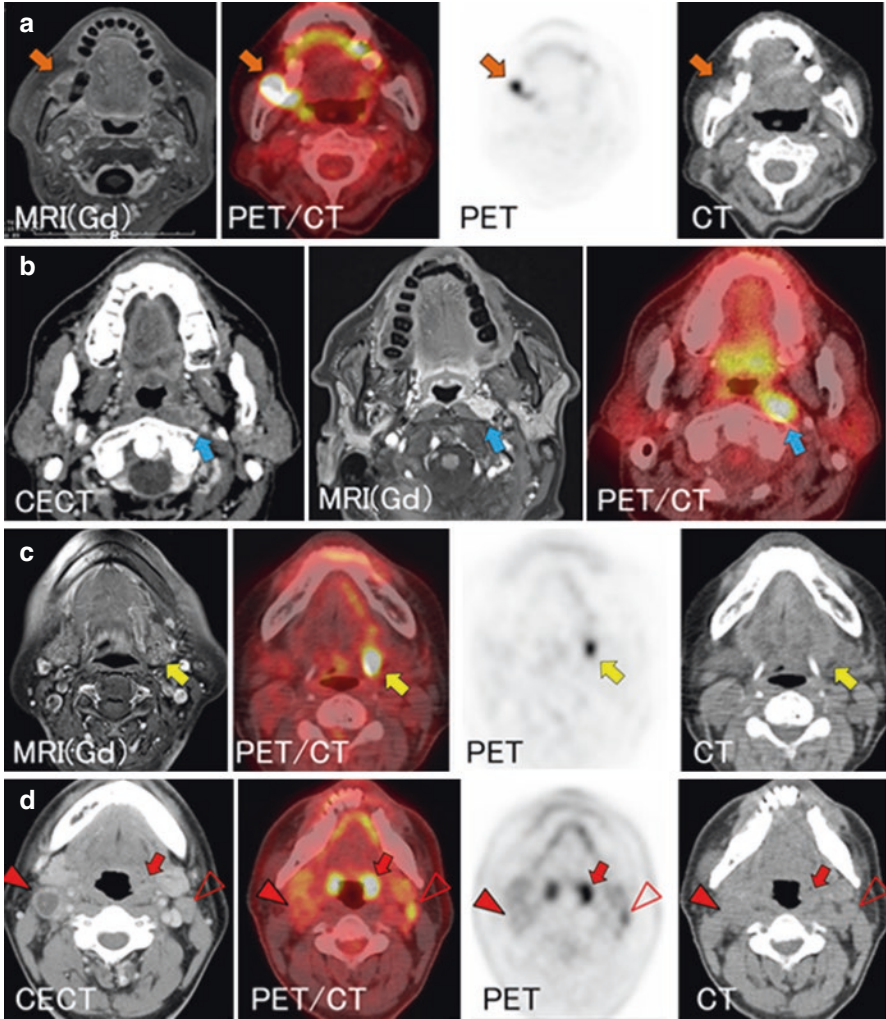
Initial staging of head and neck cancer using PET/CT. (a) An 85-year-old woman with a right lower gingival SCC (UICC eighth edition: cT4aN1M0). Contrast-enhanced MRI (left), PET/CT (second left), PET (second right), and CT (right). PET/CT clearly shows the tumor which invades into the mandible (orange arrow). (b) A 62-year-old man with a p16-positive oropharyngeal SCC involving the left tonsil. Contrast-enhanced CT (left), contrast-enhanced MRI (middle), and PET/CT (right) were performed. Retropharyngeal node metastasis on the left side (blue arrow) is most clearly identified by PET/CT, followed by MRI and CT. (c) A 79-year-old woman with a left tongue SCC (UICC eighth edition: cT4aN2bM0). Contrast-enhanced MRI (left), PET/CT (second left), PET (second right), and CT (right). A lateral lingual lymph node on the left side (yellow arrow) is not detected by contrast-enhanced MRI, while it is clearly identified by PET/CT. (d) A 52-year-old man with a left p16 positive oropharyngeal SCC (UICC eighth edition: cT1N2M0). Contrast-enhanced CT (left), PET/CT (second left), PET (second right), and CT (right). The primary tumor was in the left palatine tonsil (red arrow) with bilateral cervical lymph node metastases (arrowhead and hollow arrowhead). Contrast-enhanced CT shows cystic lymph node metastasis on the right side (arrowhead). This lymph node is not FDG-avid on PET/CT. In contrast, metastatic lymph node on the left side (hollow arrowhead) is clearly identified by contrast-enhanced CT and PET/CT
